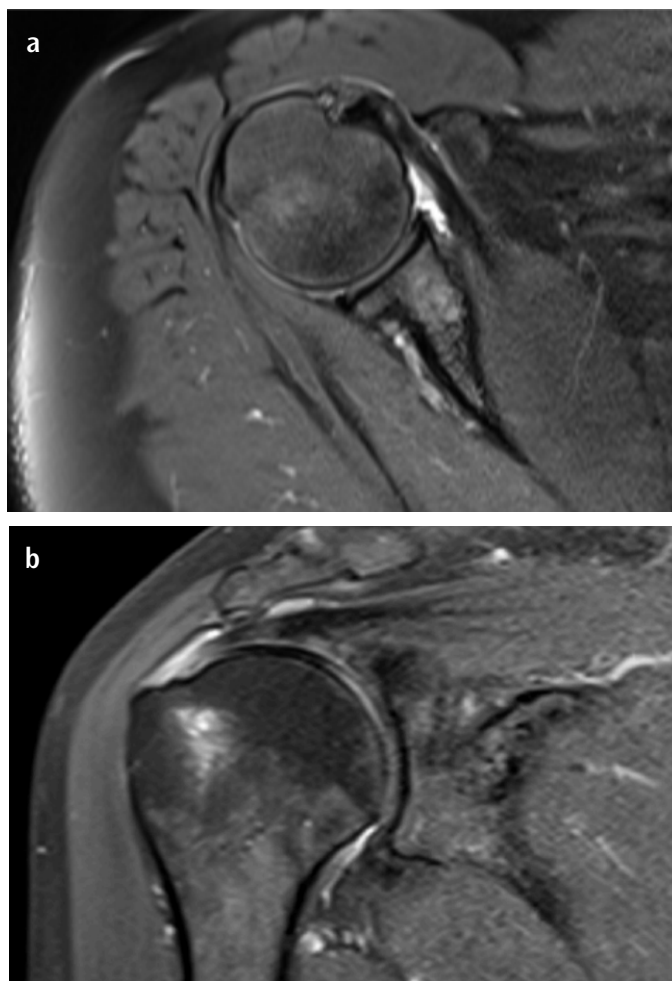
T2-weighted (a) sagittal and (b) coronal magnetic resonance images of right shoulder showing an increase in the subacromial subcoracoid bursa and intra-articular fluid in the bicipital groove (biceps tendinitis) and fluid around the subscapularis tendon (tendonitis)
